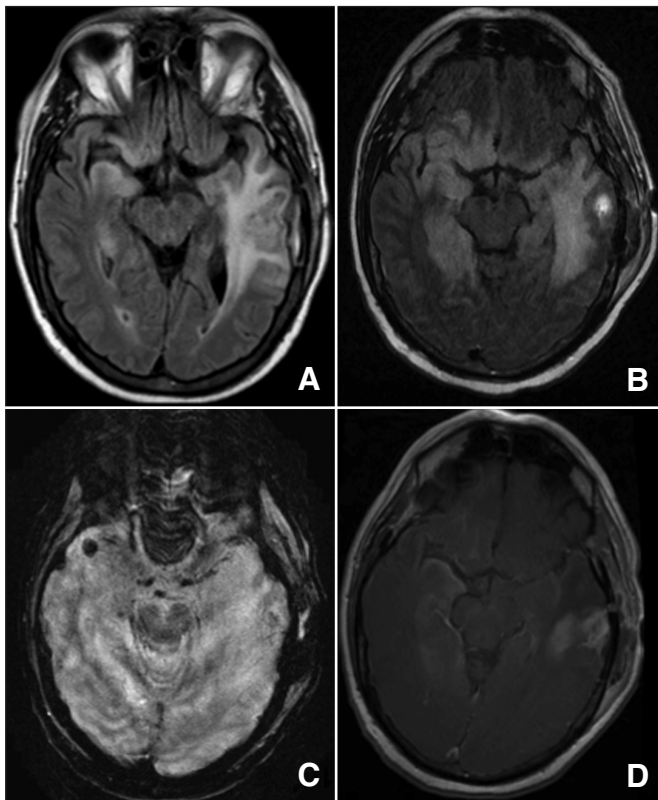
At presentation, brain MRI demonstrates bilateral mesial temporal and orbitofrontal T2 hyperintensities (A, FLAIR). After abscess drainage, further extension of hyperintense T2 signal is noted (B, FLAIR), with features of microhemorrhages (C, Gradient Echo, GRE) and bilateral meningeal enhancement (D, T1-weighted imaging with gadolinium).
